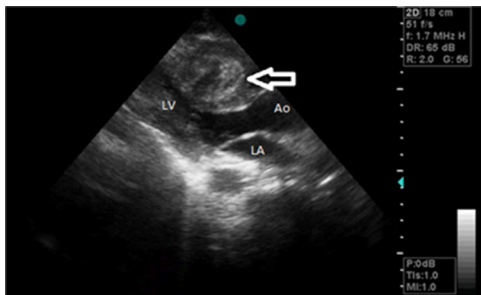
Transthoracic echocardiogram showing a heterogeneous mass (arrow), including cyst filled with fluid (from apical long axis view, LV: left ventricle, LA: left atrium, Ao: aorta).
